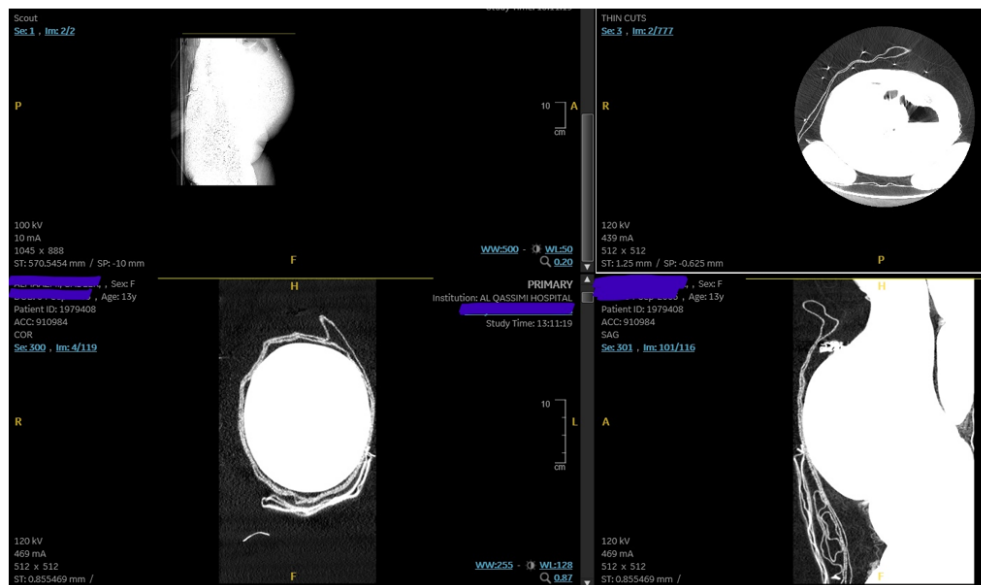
CT scan image 1.
